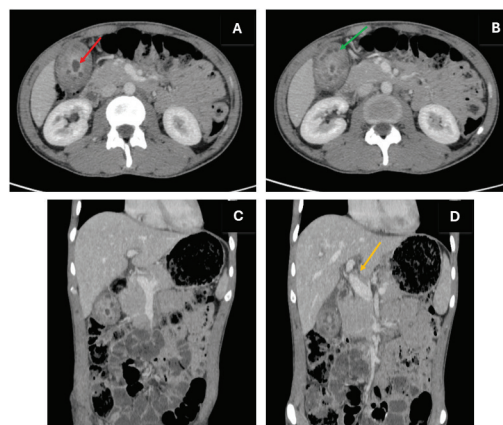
Contrast Enhanced Computed Tomography of the abdomen: Axial (A and B) and Coronal (C and D) slices revealed: Contracted gallbladder with diffuse wall thickening, hypoattenuating mural nodules and patchy mural enhancement (Green Arrow). The mucosal lining remained persistently enhanced (Red Arrow). No radiopaque gallstones and no significant pericholecystic fat stranding appreciated. The common bile duct was normal in caliber (Yellow Arrow) without a visible radiopaque calculus.
